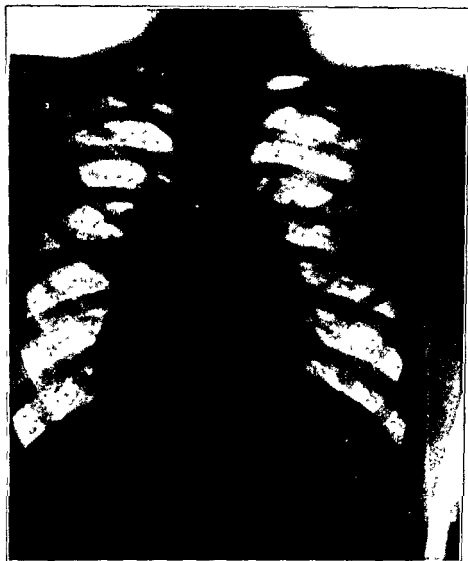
Following a six months rest in bed the boy was sent back to school. There were no complaints. Physical examination was always negative. The boy added 24 pounds of weight. An x-ray taken 15 months following the one seen in Fig. 63 shows an extension of the tuberculosis, extending now from the left apex to the second anterior rib.
